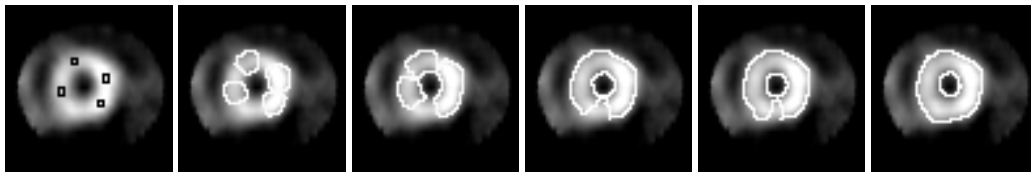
From left: Initial points of divergence, and snapshots of CCM detecting the internal and external boundaries of a LV on a short-axis cardiac SPECT.
